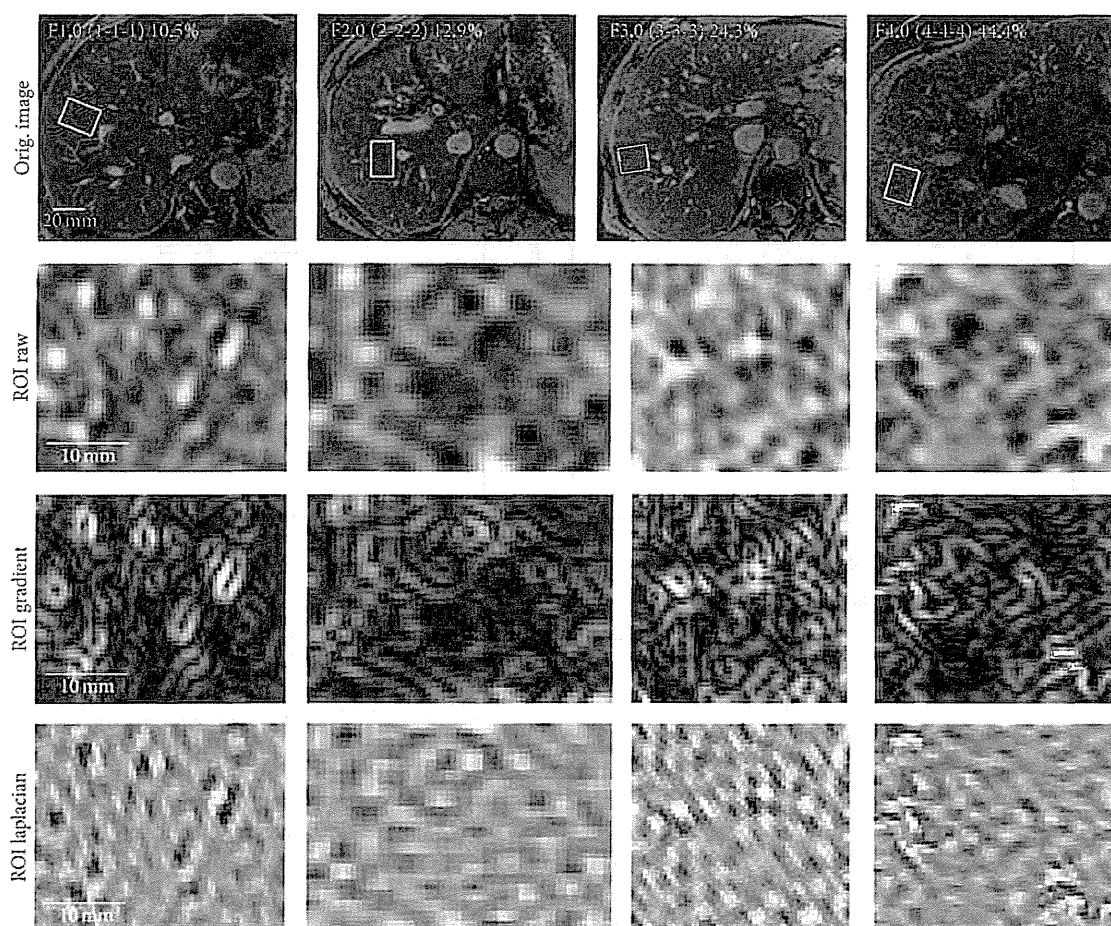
Regions-of-interest on CCE MR images in four subjects. Regions-of-interest drawn on CCE MR images in four representative subjects. Average Metavir (and individual reader METAVIR) and %-collagen scores are shown. Subjectively, high-signal reticular texture becomes increasingly conspicuous and disorganized with increasing Metavir and %-collagen scores. CCE: combined contrast enhanced.
